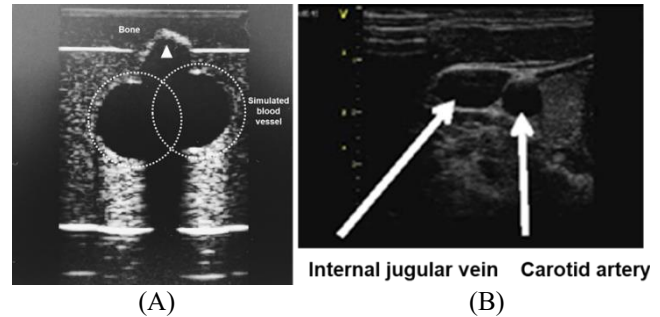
TRANSVERSE VIEW OF INTERNAL JUGULAR VEIN, (A) ULTRASOUND IMAGE OF CVC OPERATIONAL PART, (B) ULTRASOUND IMAGE ACQUIRED FROM THE REAL CASE [10]
